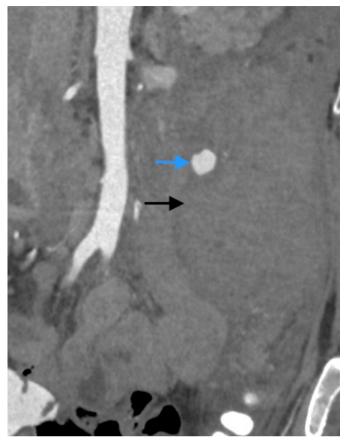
Computed Tomography Angiography in coronal view showing: a) black arrow: retroperitoneal hematoma and b) blue arrow: left colic artery aneurysm
